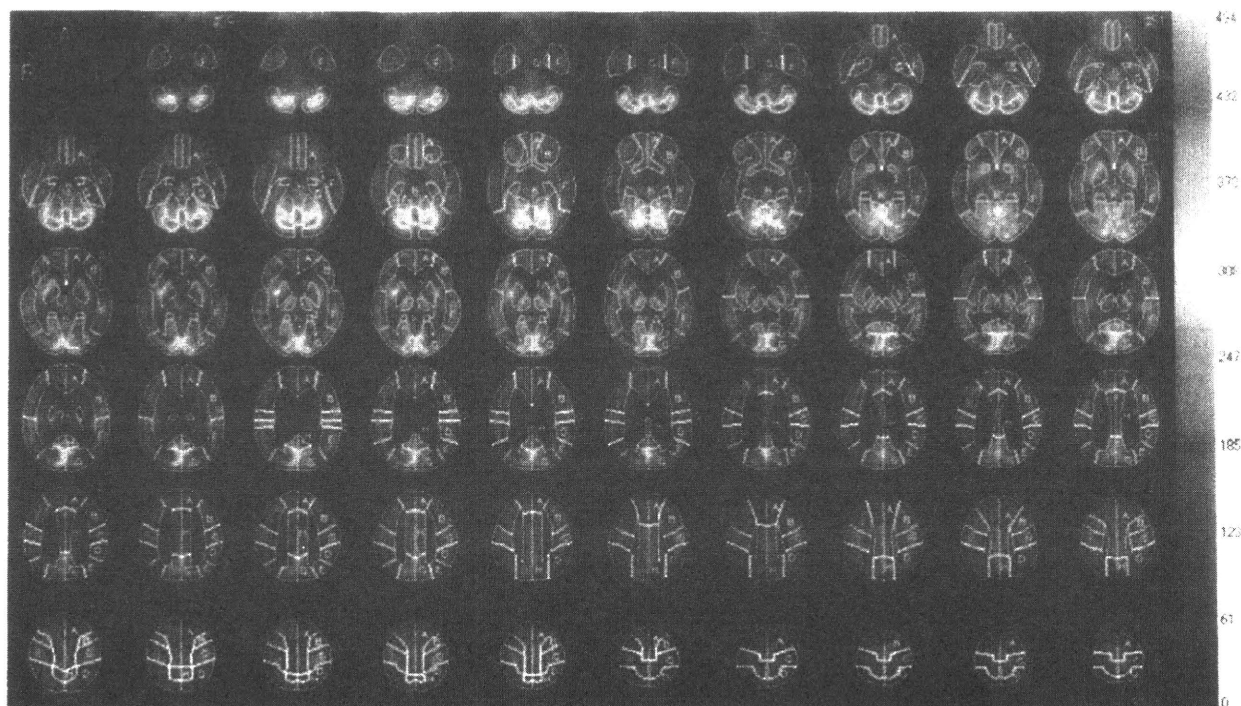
Brain perfusion single-photon emission computed tomography (SPECT) of a representative case. 3-D stereotactic region of interest (ROI) template (3DSRT) images with ROI delineation are shown on the ^{99m}Tc -ECD template. The segments are defined as follows: (A) callosomarginal, (B) precentral, (C) central, (D) parietal, (E) angular, (F) temporal, (G) posterior cerebral, (H) pericallosal, (I) lenticular nucleus, (J) thalamus, (K) hippocampus, (L) cerebellum segment. The inferior right to superior left sections correspond to the cranial-caudal horizontal sections in the subject. The left side corresponds to the right side of the horizontal sections in the subject.
